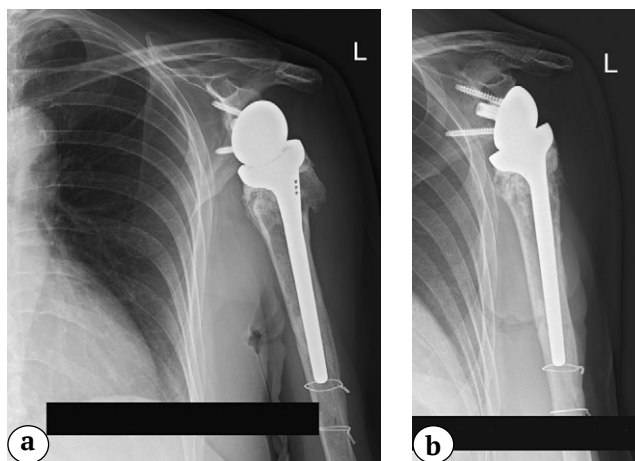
Shoulder X-rays in the early postoperative period after left shoulder arthroplasty: a – Y-shaped view; b – direct view
